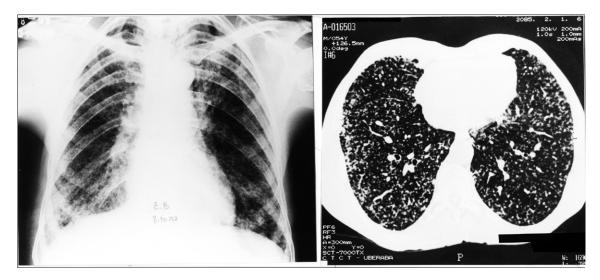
Case 1 chest x-ray and CT, showing diffuse and bilateral micronodular interstitial and linear septal infiltrate.
